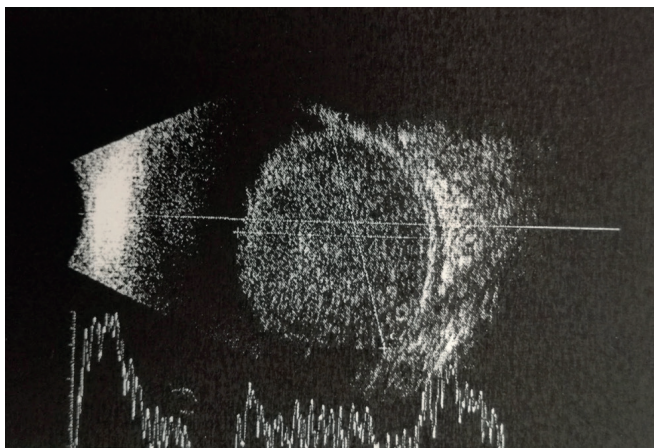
Control ultrasound – large projecting lesion in both temporal quadrants with low homogeneous echogenicity, no calcifications
